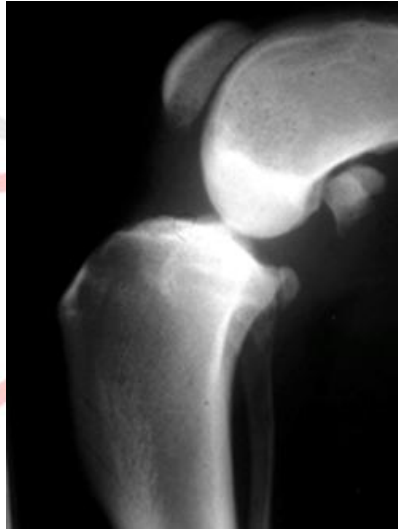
X-ray of a normal stifle joint.
